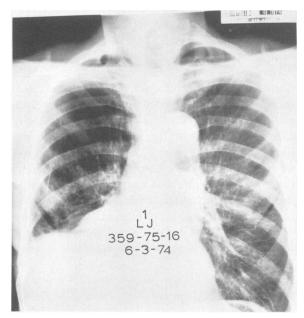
Admission roentgenogram of chest showing pleural effusion and suggestion of mass in right lower lobe. Note extensive bullous changes at both apices.
